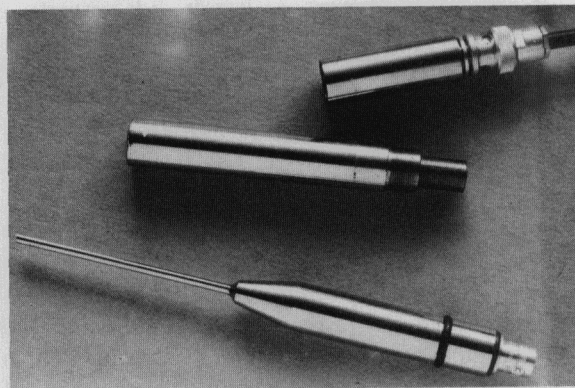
Ultrasonic probe for measuring bone thickness.
